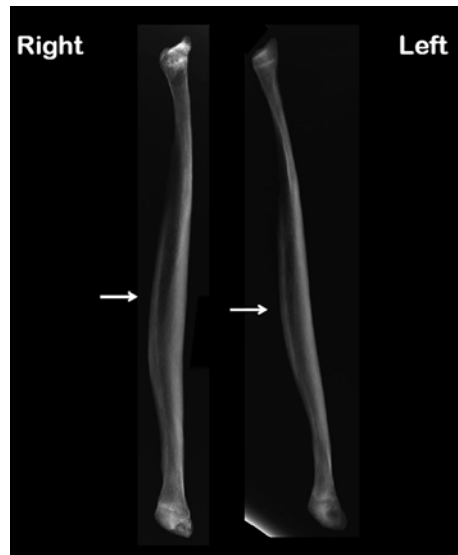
(a) AP radiographs of the tibiae revealing lateral angulation of approximately 20° on the right and 10° on the left. (b). AP radiograph of both tibiae displaying multiple transverse linear radiopacities suggestive of Harris' *arrest lines*, several indicated by *arrows*, on the medial aspect bilaterally
